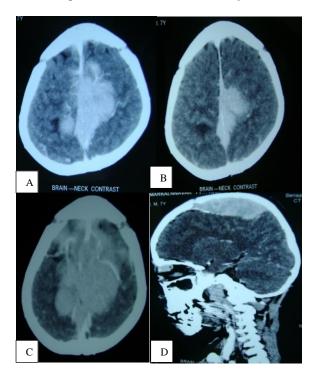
(A-D): Plain and contrast CT brain and neck revealed an epidural mass extension along falx with bilateral orbital soft tissue lesions. Also showing expansile lytic destruction of left mandibular ramus with soft tissue components.
